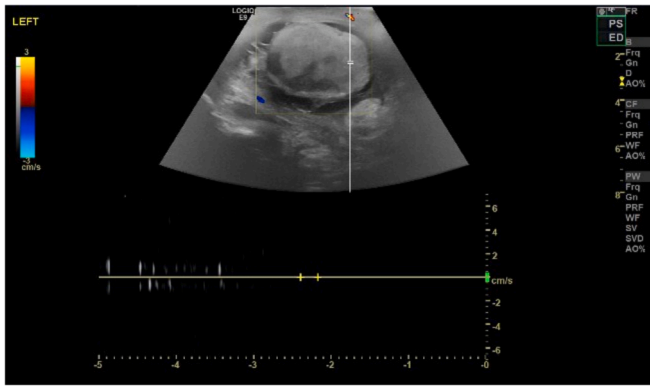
The ultrasound image of our patient demonstrated a heterogeneous left testis with multiple areas of low echogenicity, and absent color doppler flow.
